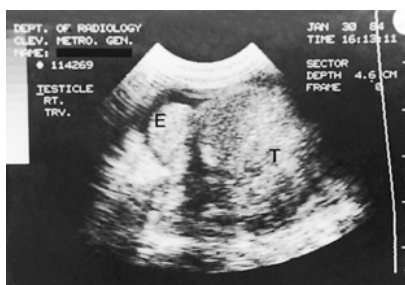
34. Scrotal ultrasound demonstrating changes typical of chronic epididymitis. Note enlarged hyperechoic epididymis (E) and normal testicle (T).
